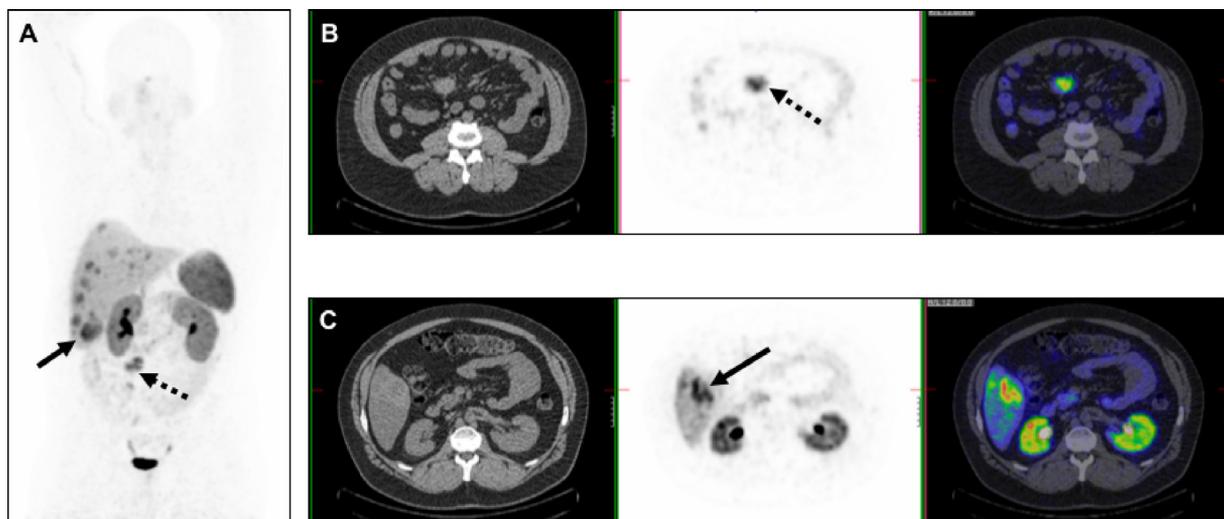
^{68}Ga -DOTATATE PET scan for somatostatin receptor imaging. (A) MIP image demonstrating primary mesenteric lesion (dotted arrow) and multiple liver metastases, with the largest lesion in segment 5 (solid arrow). (B) Axial images of the mesenteric lesion on CT, PET and fused PET/CT images. (C) Axial images of the largest liver lesion on CT, PET, and fused PET/CT images.
